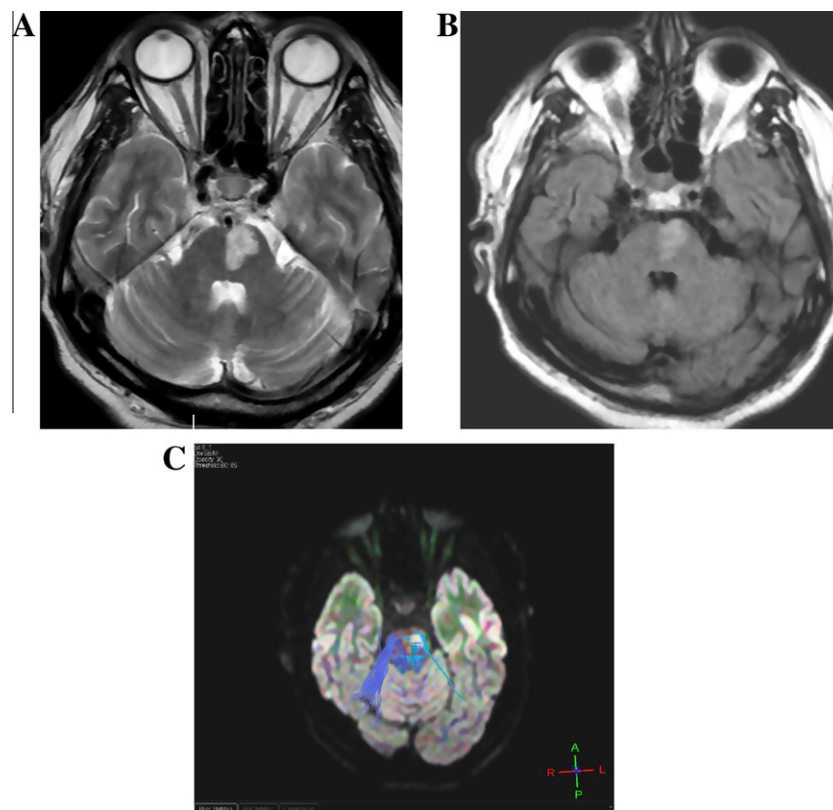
Patient # 20. (A and B) The T2 weighted axial image and the corresponding FLAIR image showed hyperintense region of subacute infarction in the left side of the pons. (C) The DTT colored image based on DWI showed near total disintegration of the corticobulbar tract fibers on left side in comparison with the right sided tract associated with poor outcome of this patient.
